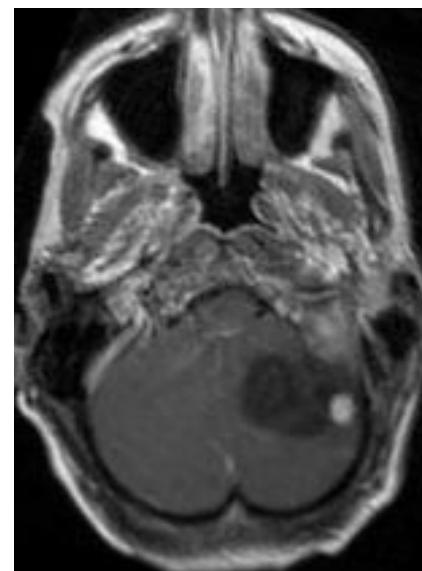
T1-weighted gadolinium enhanced brain magnetic resonance image. Axial section, through the posterior fossa showing a cerebellar haemangioblastoma. Courtesy of Dr Jay Krishnan, Department of Neuroradiology, Newcastle General Hospital.
